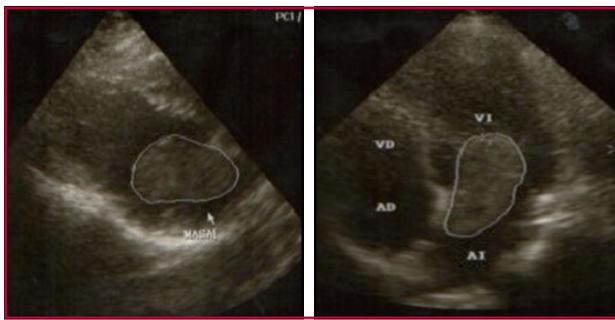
A. Echocardiography showing tumor image.
